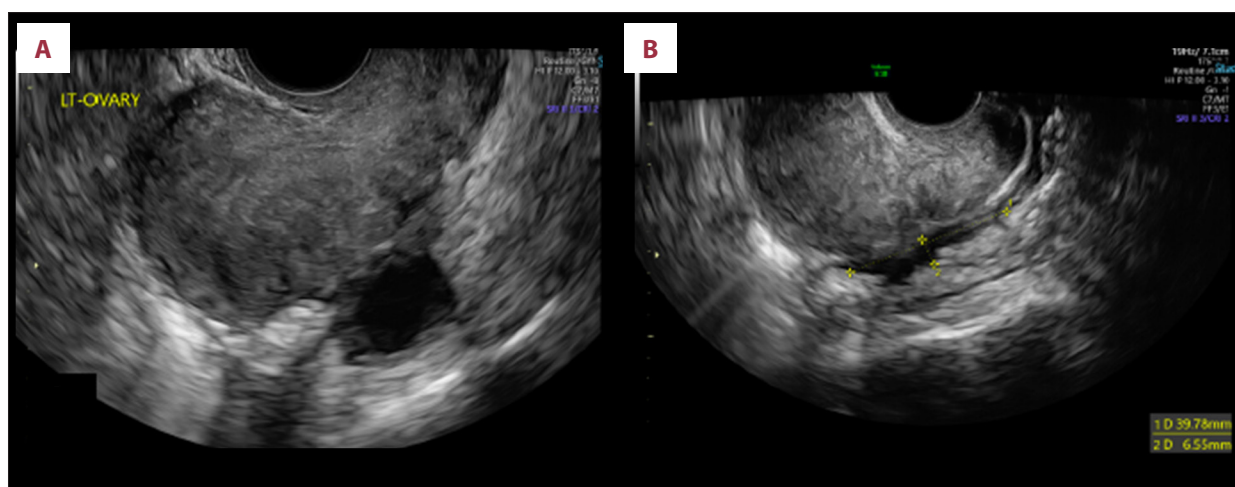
Vaginal ultrasound. Uterine forced retroflexion with signs of diffuse adenomyosis and a typical endometrioma on the left ovary (20 mm) (A). A nodule of infiltrating deep endometriosis in the rectosigmoid region (B).
